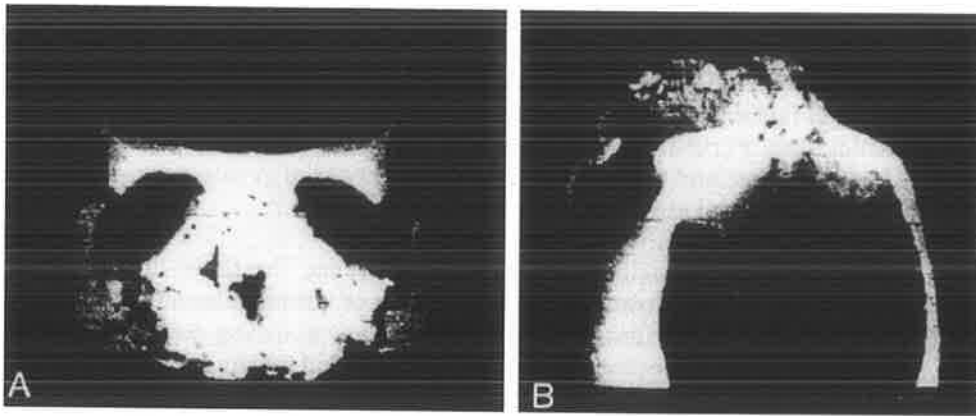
A. anteroposterior (AP) view of severe facial fracture demonstrates disruption of the orbits with lateral displacement of the zygomatic bones and complex nasoethmoidal maxillary fractures. The skull above the orbits, behind the interaural line, and below the maxilla has been eliminated because it is not of interest. B. a superior rotational view of the same patient shows the cranial fossa and the cribriform plate demonstrating that the anterior cranial fossa and the posterior wall of the frontal sinus are intact. The cribriform plate on the left is clearly normal. This view also demonstrates disruption of the zygomatic complex bilaterally and the fact that the fractures are entirely subcranial (The defect in the floor of the middle cranial fossa is artifactual because the last CT slice was obtained above this level).
